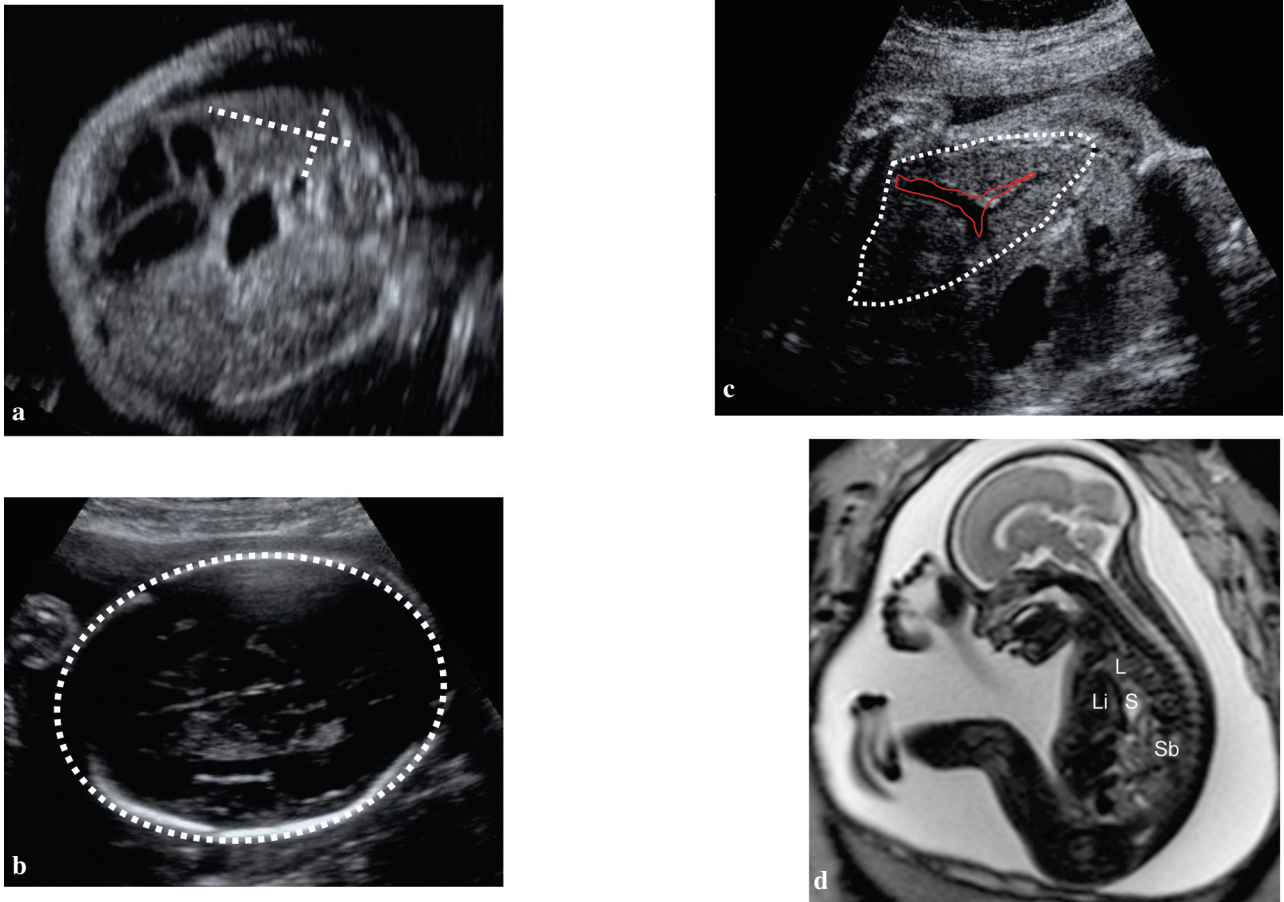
Fetus with congenital diaphragmatic hernia (CDH). (a) Measurement of the Lung-to-Head Ratio in a section through the so-called four chamber view with the so-called “longest axis method”: the contralateral lung is measured by multiplying the lung’s longest axis by the longest measurement perpendicular to the former one. Its value is proportionated over the head circumference (b), measured in the standard biparietal view, showing two symmetrical hemispheres, the cavum septum pellucidum at one third of the fronto-occipital diameter and the posterior horns of the lateral ventricles. (c) Herniation of the liver. The major vessels help in its identification. (d) MR images of a fetus with CDH in the second trimester. L = lung; Li = liver, S = stomach, Sb = small bowel.
